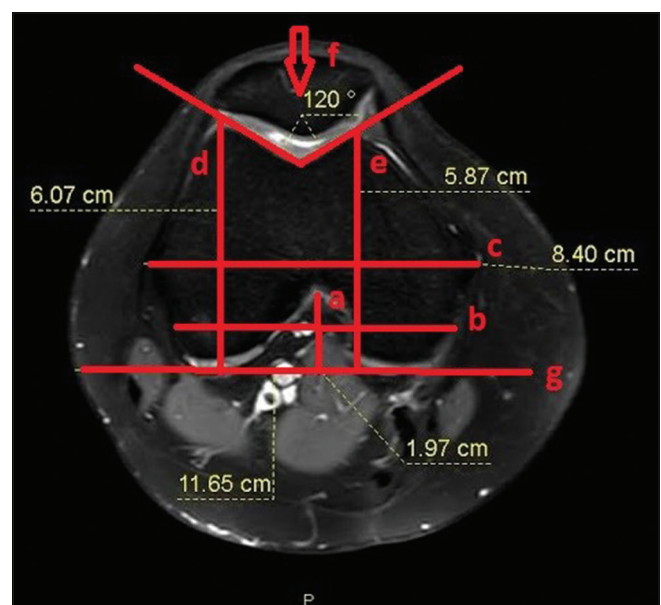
Axial magnetic resonance image of distal femur. a: NH, b: NW, c: FML, d: FLAP, e: FMAP, f: TGA, g: Reference line
